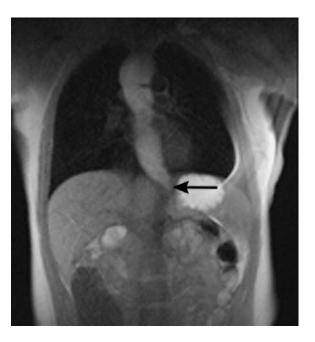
Fluoro MRI of the esophagus. Cine-Turbo-FLASH T1 weighted sequence acquired on coronal plane during ingestion of a solution of GD-DTPA (1%) mixed with water showing esophageal achalasia. The lack of relaxation of low esophageal sphincter (*arrow*) as well as low third esophageal dilatation during ingestion of oral contrast agent is well visible
